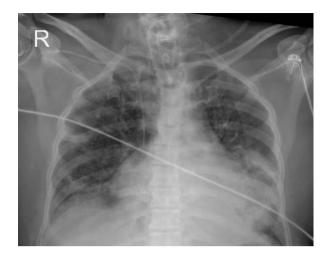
Chest X-ray AP view showing the position of endotracheal tube and left sided pleural effusion
